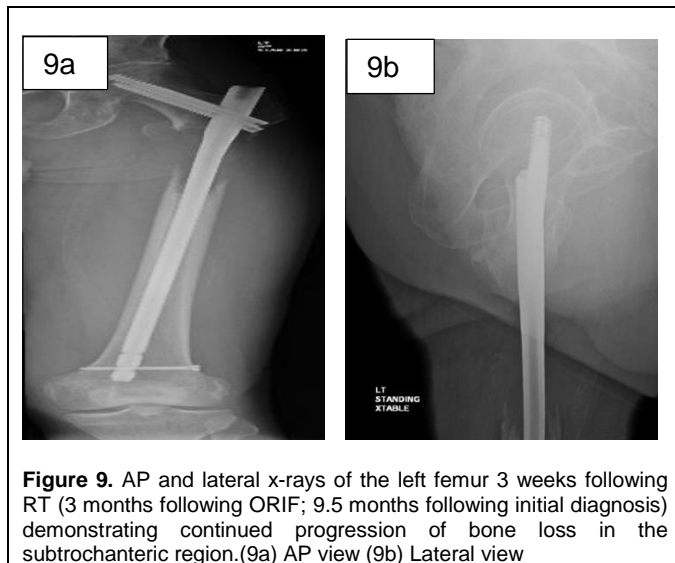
AP and lateral x-rays of the left femur 3 weeks following RT (3 months following ORIF; 9.5 months following initial diagnosis) demonstrating continued progression of bone loss in the subtrochanteric region.(9a) AP view (9b) Lateral view
